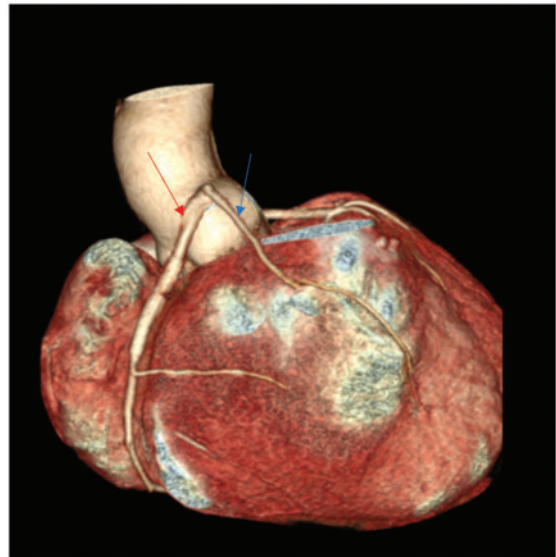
Computed tomography scan: showing the origin of the right coronary artery (red arrow) from the anterior wall and the left main (black arrow) from the posterior wall because a counter clockwise rotation of the aorta. The accessory left anterior descending artery (blue arrow) take off from the proximal right coronary artery.
